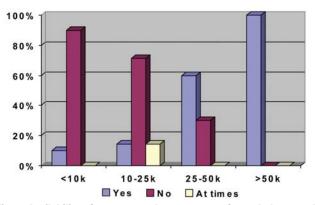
Availability of emergency department-performed ultrasound to annual ED volume.
